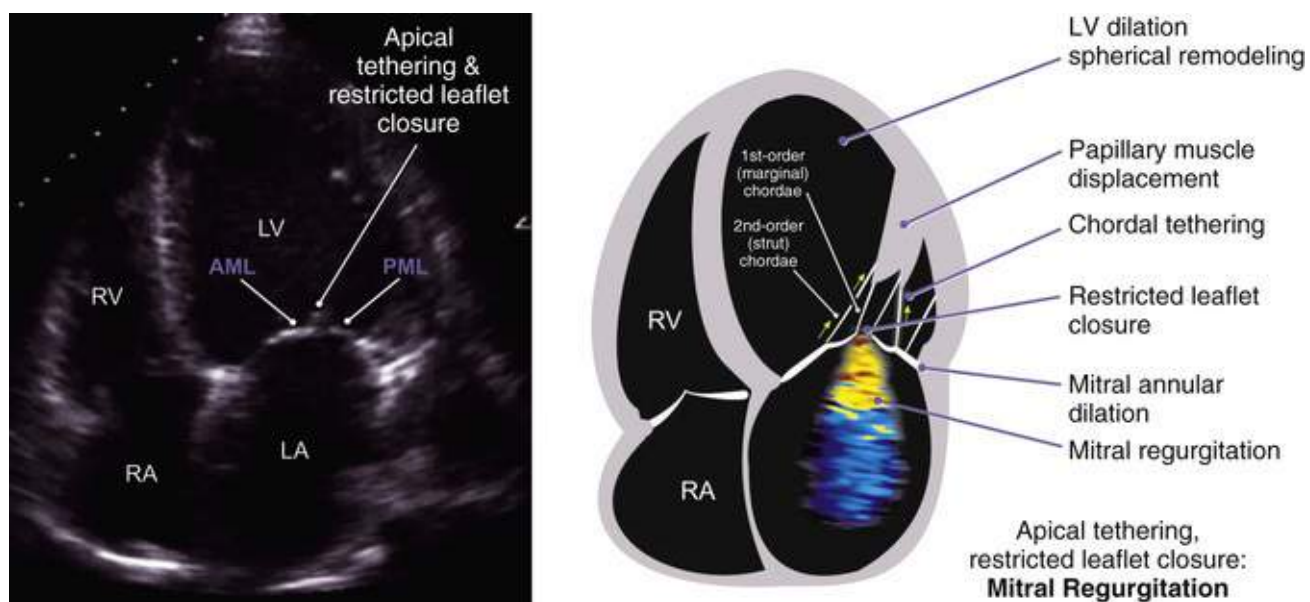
Functional/ischemic MR. Mitral tethering forces are increased because of both annular dilation and papillary muscle traction, which occur as a result of LV remodeling. Closing forces are reduced because of impaired LV systolic function. The end result is apical displacement of leaflet coaptation, as shown in the apical four-chamber view on the left. AML, Anterior mitral leaflet; LA, left atrium; LV, left ventricle; PML, posterior mitral leaflet; RA, right atrium; RV, right ventricle.
